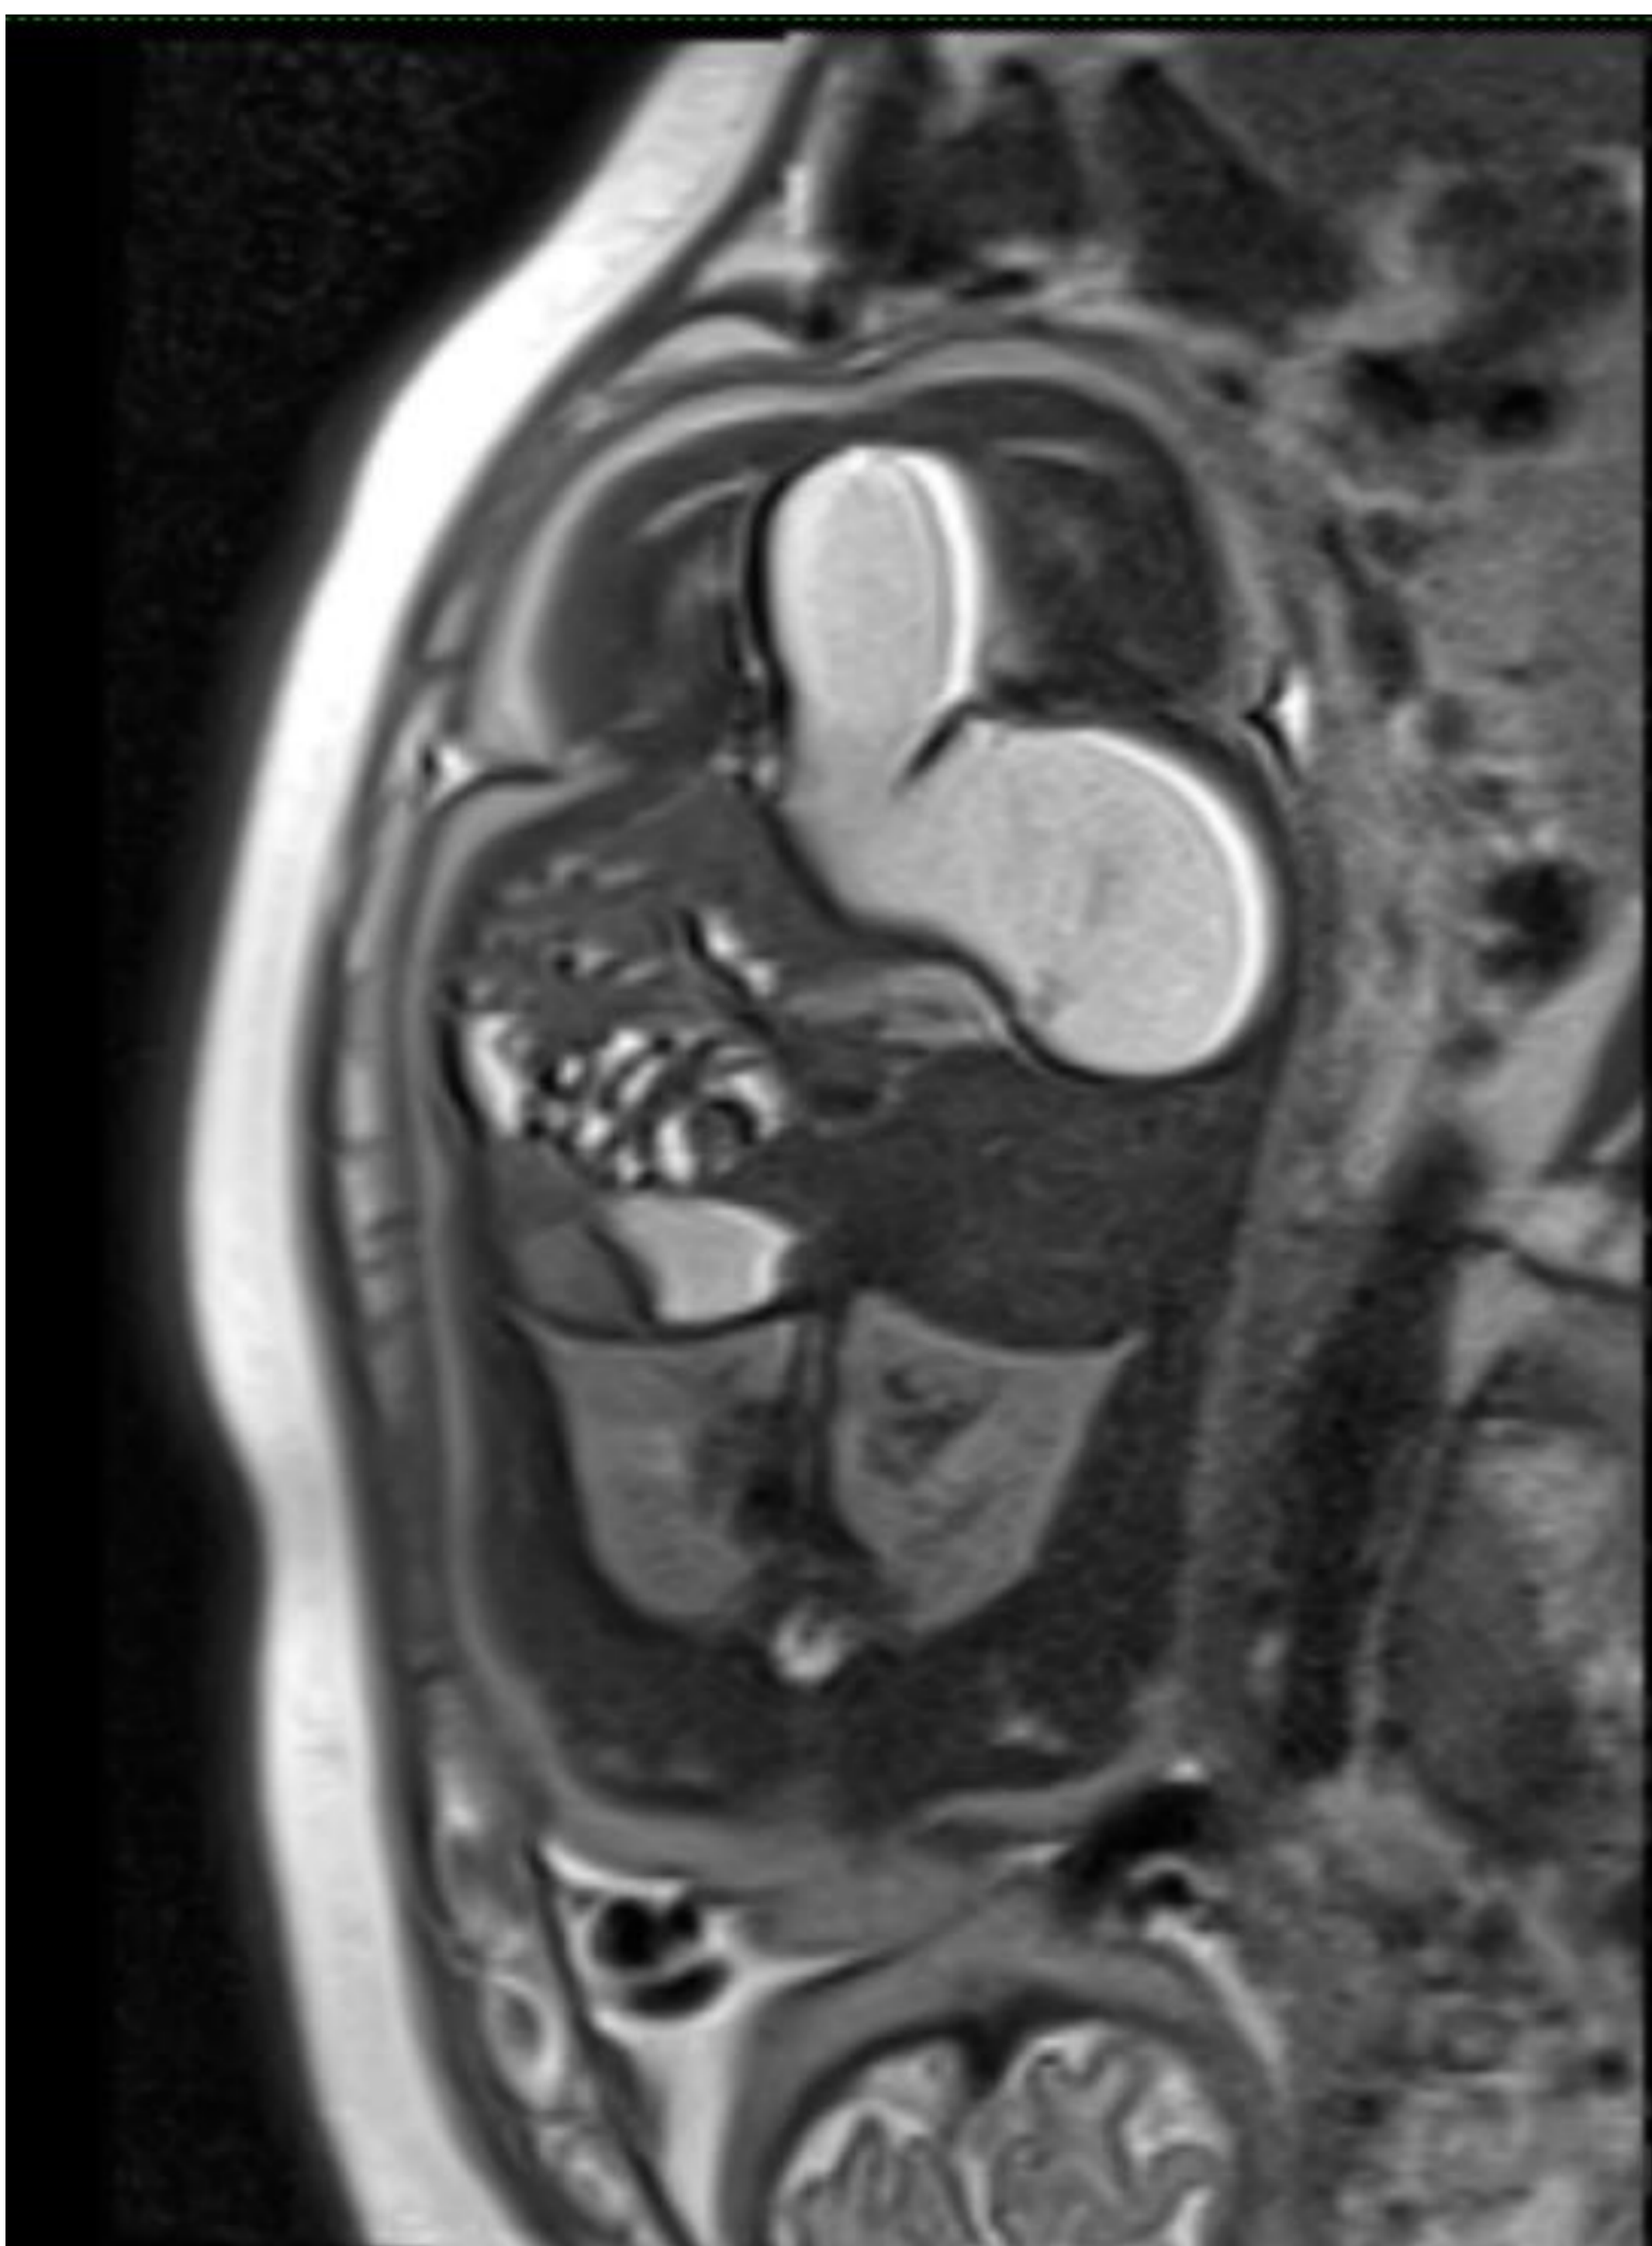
Antenatal MRI showing a grossly distended sigmoid colon on right side of abdomen.
